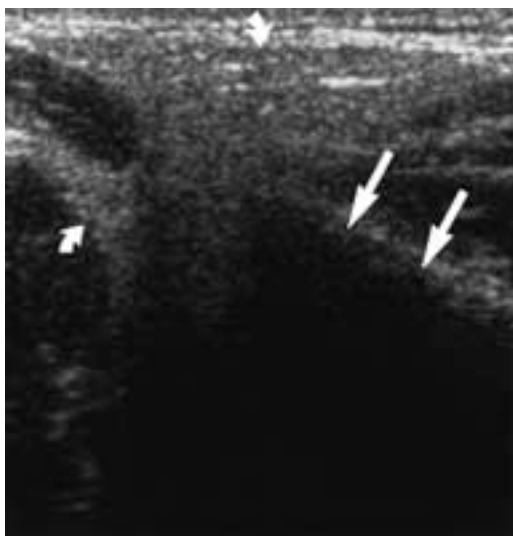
This axial image shows the parotid gland (*curved arrows*) with a homogeneous, hyperechoic appearance. Ultrasound cannot visualize the part of the deep portion of the gland that extends deep to the mandible (*straight arrows*), which is the anechogenic area on this image.
